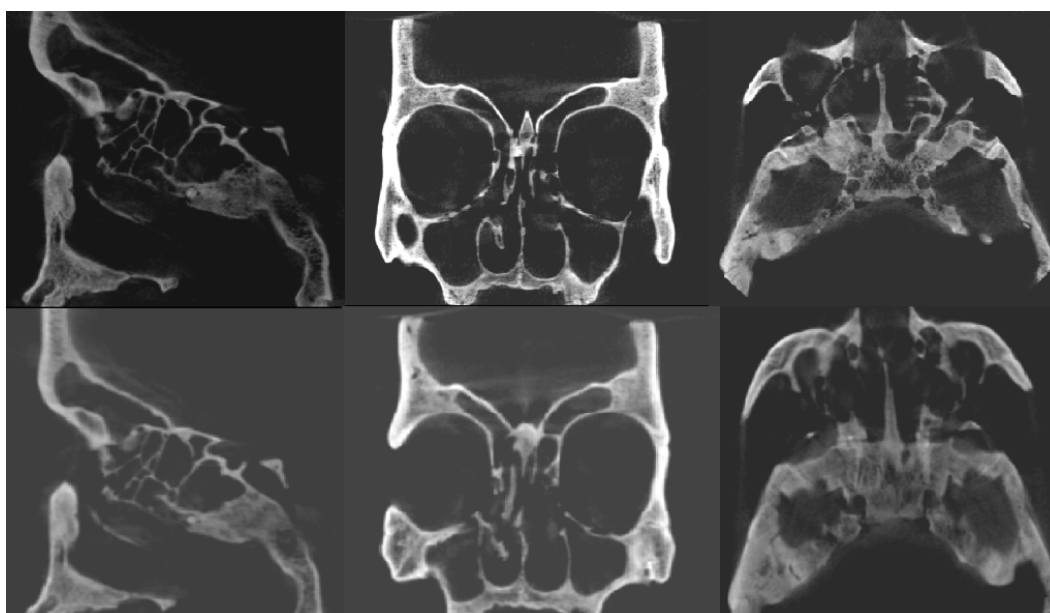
(upper row) High-resolution CBCT in axial, coronal and sagittal sections from right to left; (lower row) low-resolution CBCT in axial, coronal and sagittal sections from right to left
